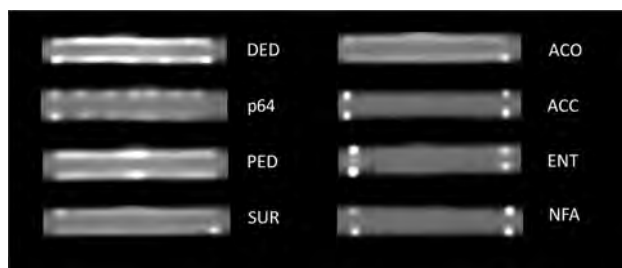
CT of the examined devices. *Left column:* flow diverters. *Right column:* conventional stents. The windowing was adjusted according to the lowest artifact interference of all stents (same settings for all devices).
